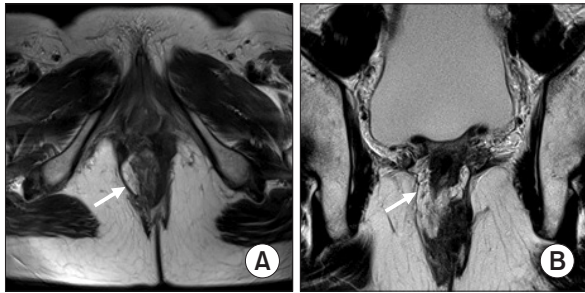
Pelvic magnetic resonance imaging after hemilevator excision: obliterated defect of excised right levator-ani muscle by fibrotic tissue (white arrow). Axial (A) and coronal (B) view.
